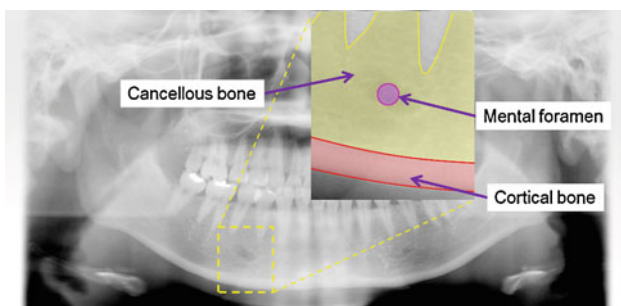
Dental panoramic radiograph and the enlarged view near the mental foramen
